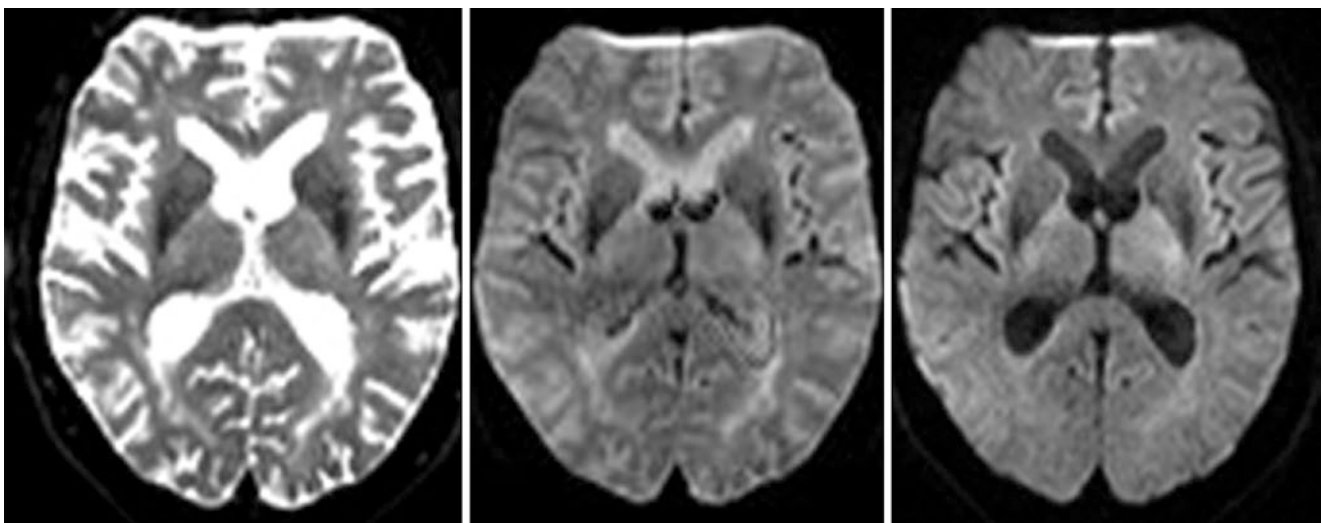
A 71-year-old with a normal 3 T MRI. DWI was obtained with b values of 0 (*left*), 500 (*middle*), and 1000 (*right*) s/mm^2 . Note that the closer the b value is to zero, the more the image appears to be a rudimentary T2WI, whereas at higher b values, the CSF becomes quite dark
